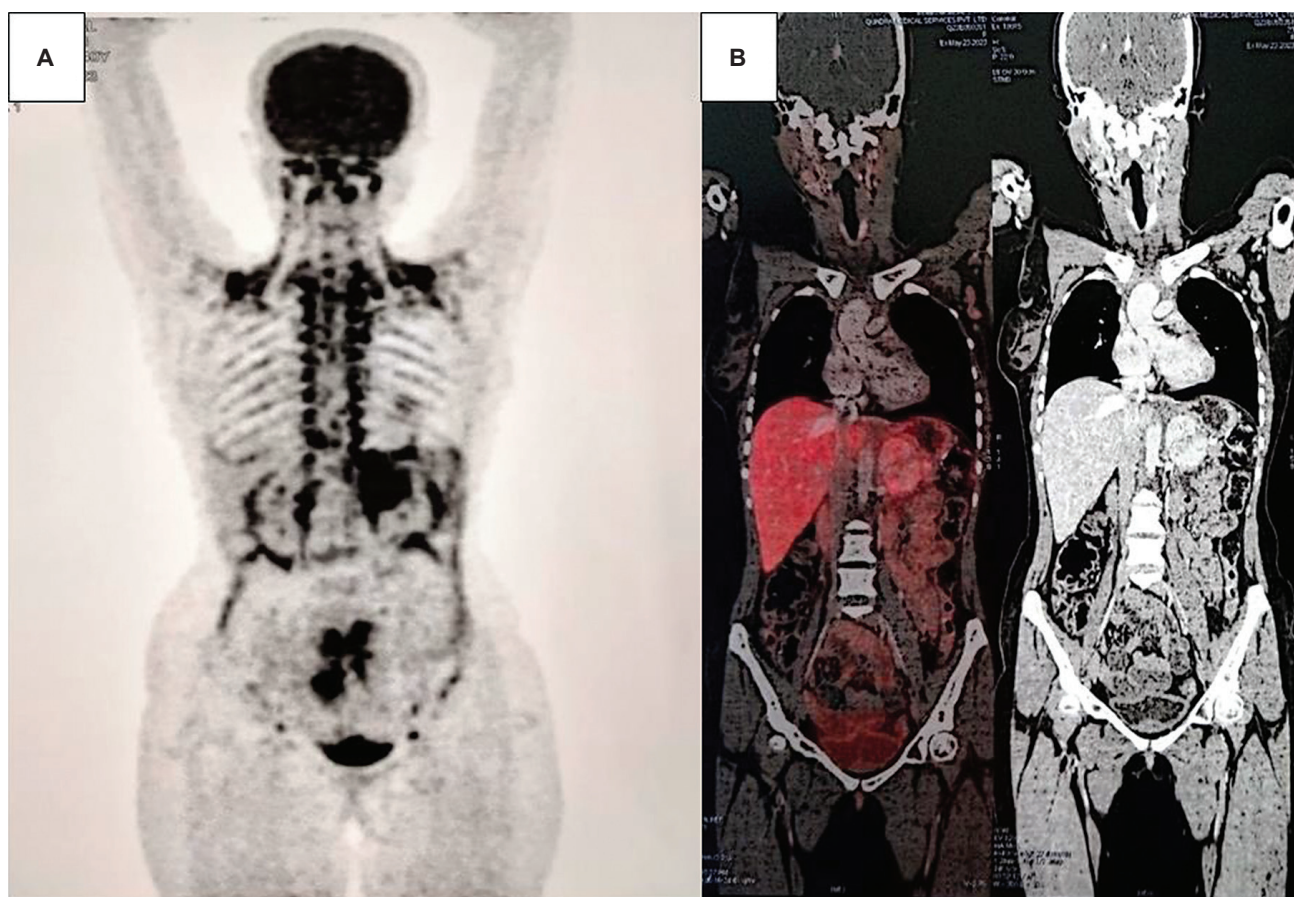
(A) 18-FDG PET CT done showed a large left adrenal mass, mediastinal, abdominopelvic lymph nodes, metabolically active mesenteric, peritoneal, and omental thickness suggestive of brown fat uptake; (B) Ga-68 DOTANOC PET CT showing a diffuse somatostatin receptor-expressing large soft tissue mass lesion in left adrenal likely pheochromocytoma.
